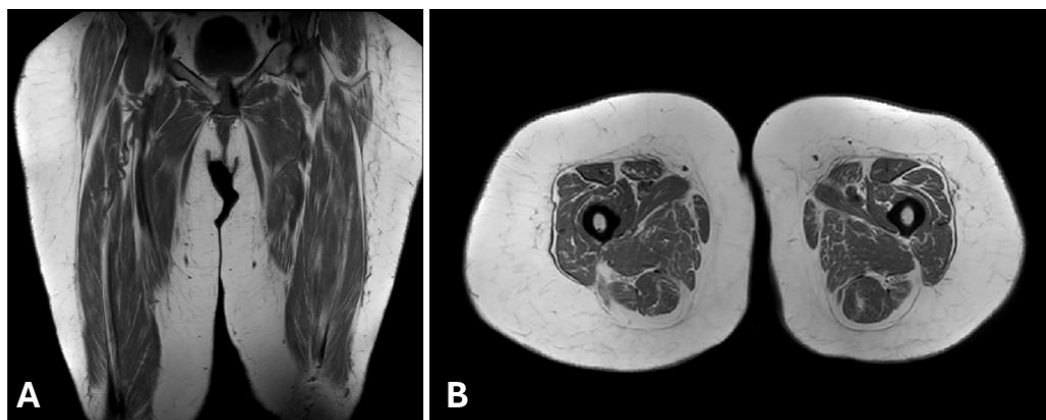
A. Longitudinal section of the lower limb. B. Transverse section of the lower limb. Hyperintense signal on T2-weight MRI sequences consistent with inflammatory edema.
